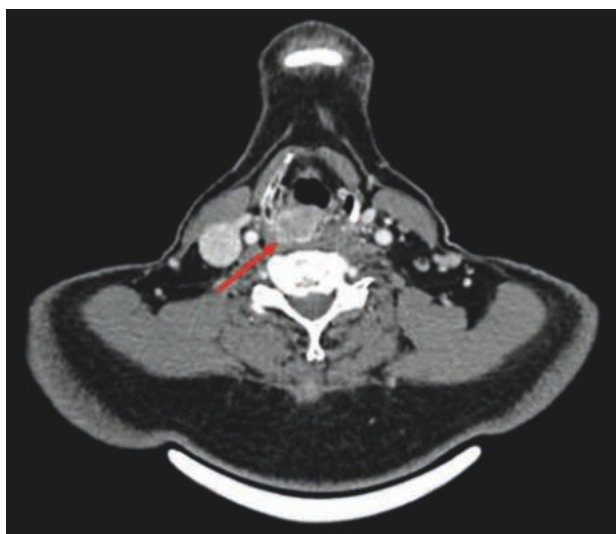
Axial view computed tomography scan demonstrating soft tissue mass overlying the right arytaenoid cartilage (red arrow) abutting thyroid cartilage.
